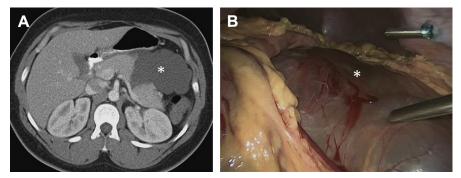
(*A*) Axial CT showing a large multilobulated cystic mass in the lesser sac arising from the body of the pancreas causing abdominal pain in a 22-year-old woman. Asterisk indicates cyst. (*B*) Intraoperative picture of a cystic lesion of the tail of the pancreas. Limited pancreatic resection and excision of the mass confirmed complete resection of a 15-cm lymphangioma with resolution of the patient's symptoms. Asterisk indicates cyst.
